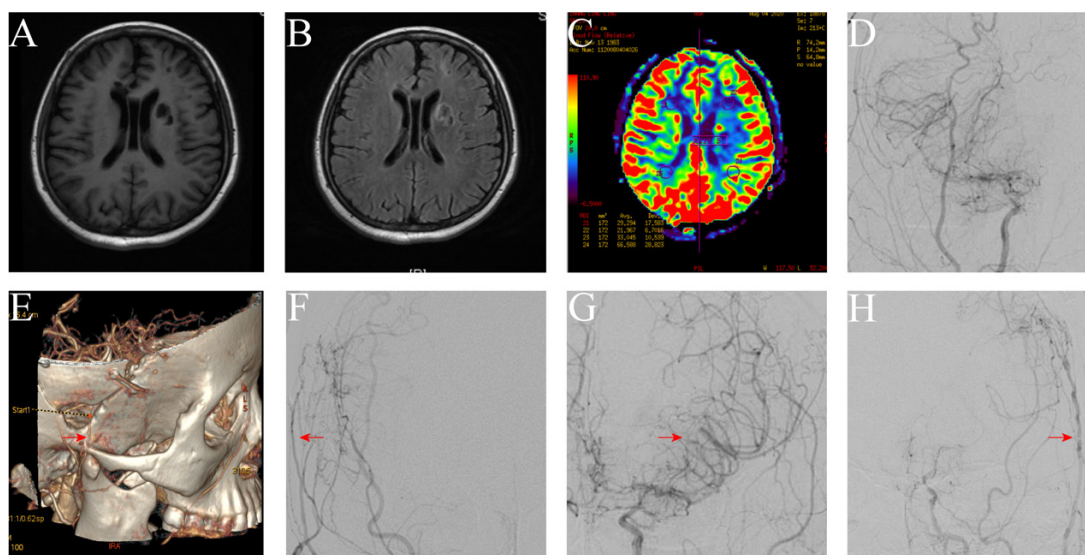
Image of Case 2. (A, B) Multiple hypointense on T1WI and hyperintense on T2WI lesions in the left frontal lobe, left basal ganglia, bilateral corona radiata, and right genu of the corpus callosum. (C) MRI shows decreased cerebral perfusion in the left cerebral hemisphere. (D) An anteroposterior view of the right cerebral hemisphere before the procedure. (E) Postoperative CTA showing the right superficial temporal artery (arrow). (F) Anteroposterior view of the right cerebral hemisphere after the STA-MCA bypass surgery. (G) An anteroposterior view of the left cerebral hemisphere before the procedure. (H) Lateral view of the left cerebral hemisphere after EMS procedure.
